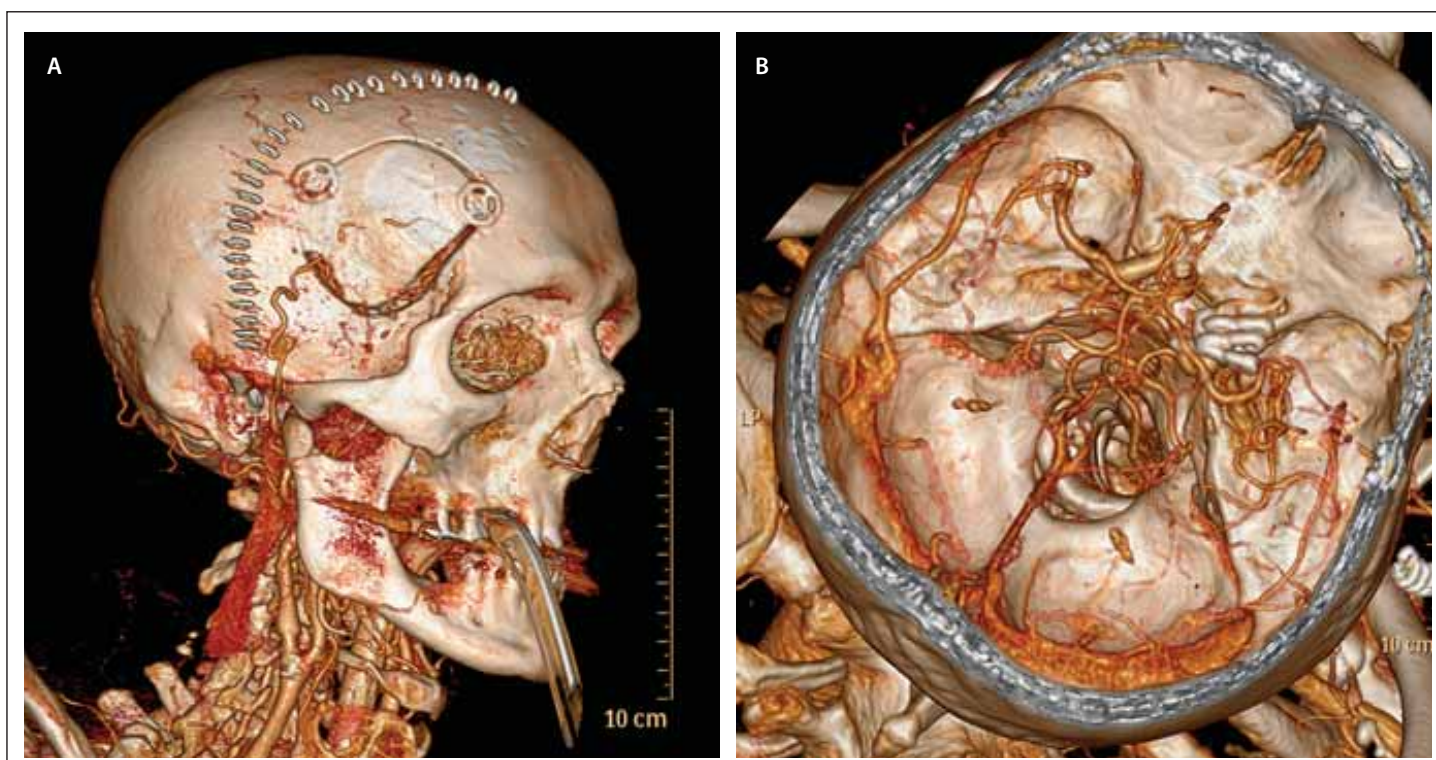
Postoperative 3D CTA. (A) The STA-MCA prophylactic bypass is apparent. (B) Three tandem fenestrated clips were used to exclude the aneurysm from circulation.
